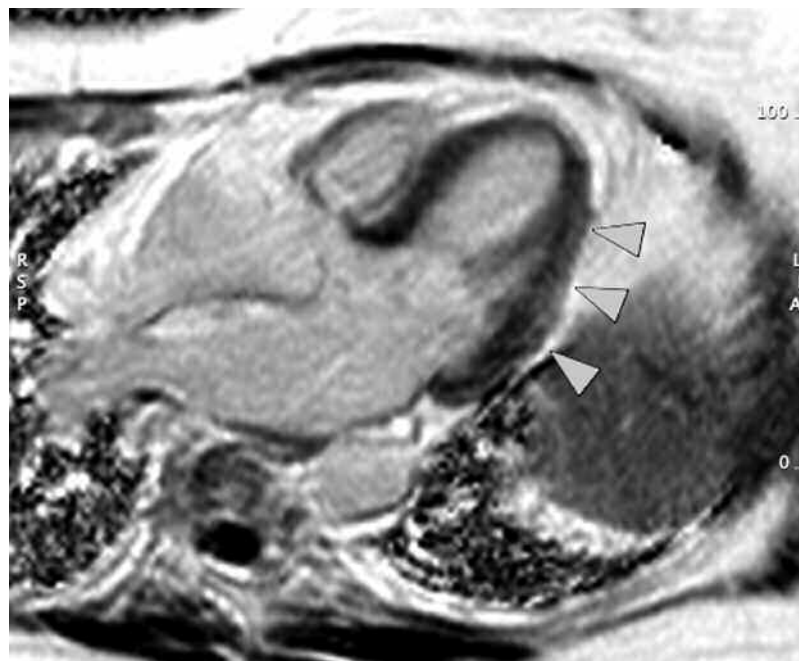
Repeat cardiac MRI 13 months later. No interval change in late enhancement.
